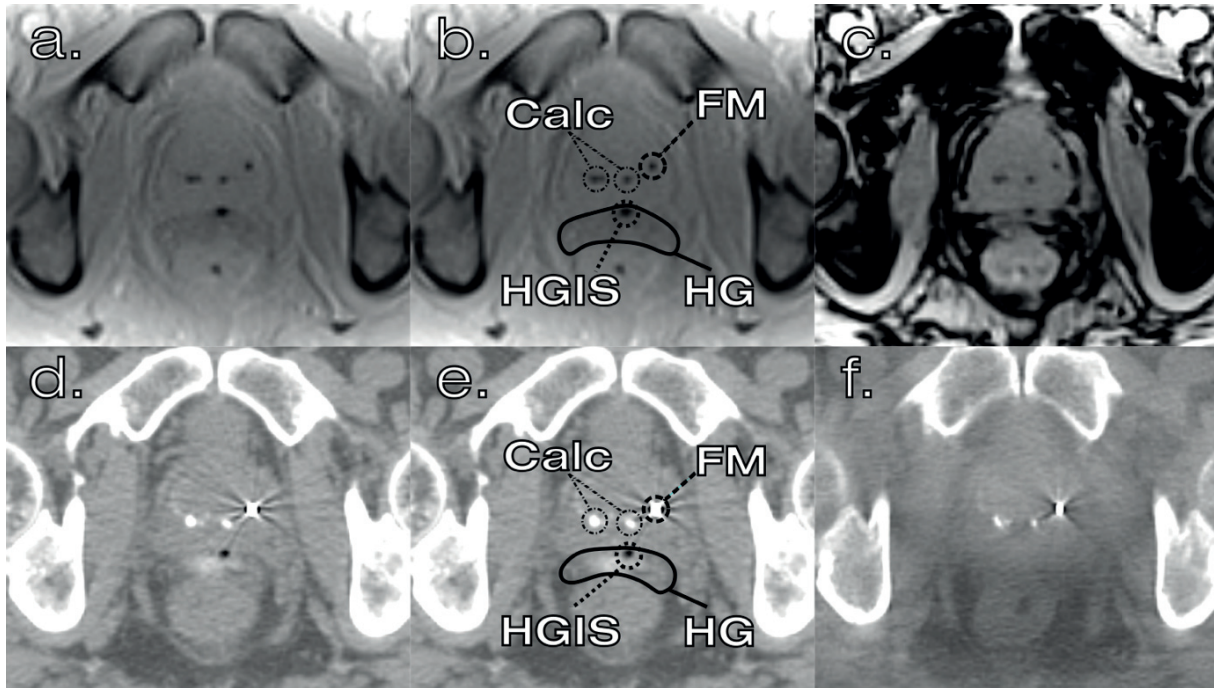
MRI (a,b,c) and CT (d,e,f) images of an axial section of prostate anatomy. MRI images acquired using the T₁-VIBE sequence at 1.23ms and 2.46ms echo times are shown in (a) and (c) respectively. Radiotherapy planning CT and pre-treatment CBCT images are shown in (d) and (f) respectively. Annotated 1.23ms echo time T₁-VIBE and CT images are shown in (b) and (e) respectively. Fiducial markers (FM), calcifications (Calc), hydrogel spacer (HG) and hydrogel spacer injection sites (HGIS) structures are annotated.
